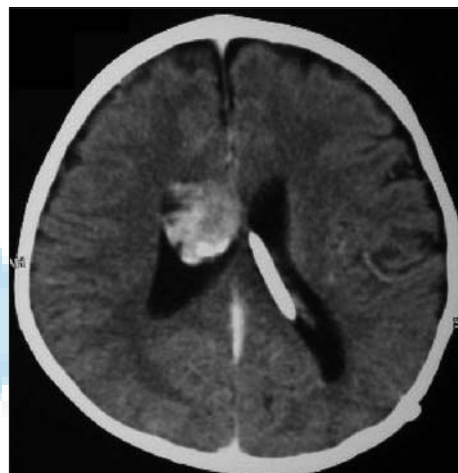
Contrast-enhanced computed tomography scan done after 4 months showing the choroid plexus papilloma to have migrated to the frontal horn of the right lateral ventricle. The left-sided ventriculoperitoneal shunt is seen
